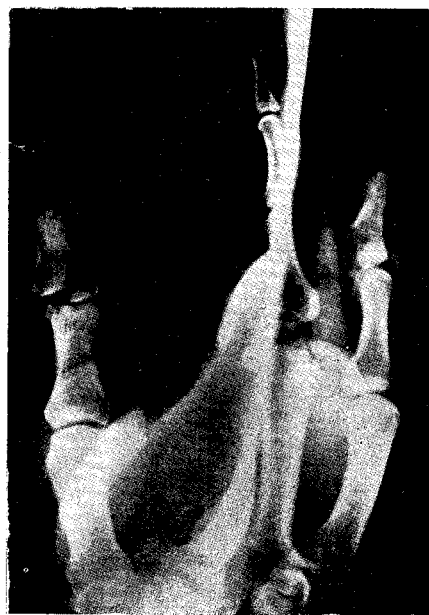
X-ray -Fracture of the base with disruption of joint interphalangeal joint level. On 9.9.73 the gangrenous portion of the thumb was removed leaving a large volar defect. This was covered by a cross-finger flap from the back of the index metacarpal and proximal phalanx. The radial nerve fibres to this flap were dissected out and transferred into the thumb (Fig. 2). The flap was divided and inset to the thumb on 30.9.73. The patient had good sensation in the flap referred to the dorsal aspect of the index finger, from the time it was transferred. He made excellent progress. He was able to use the thumb well within a few weeks. The flap was
